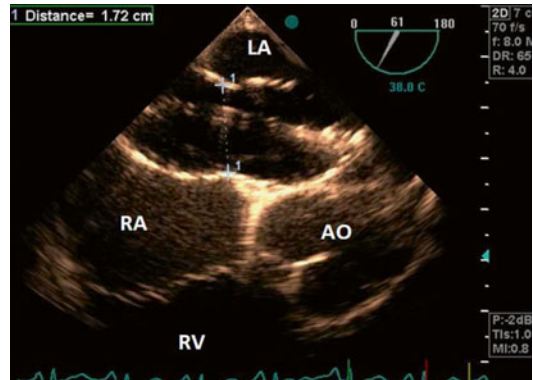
Transesophageal echocardiography showing how to measure the balloon stretch diameter of the ASD. RV right ventricle, RA right atrium, AO aorta, LA left atrium
